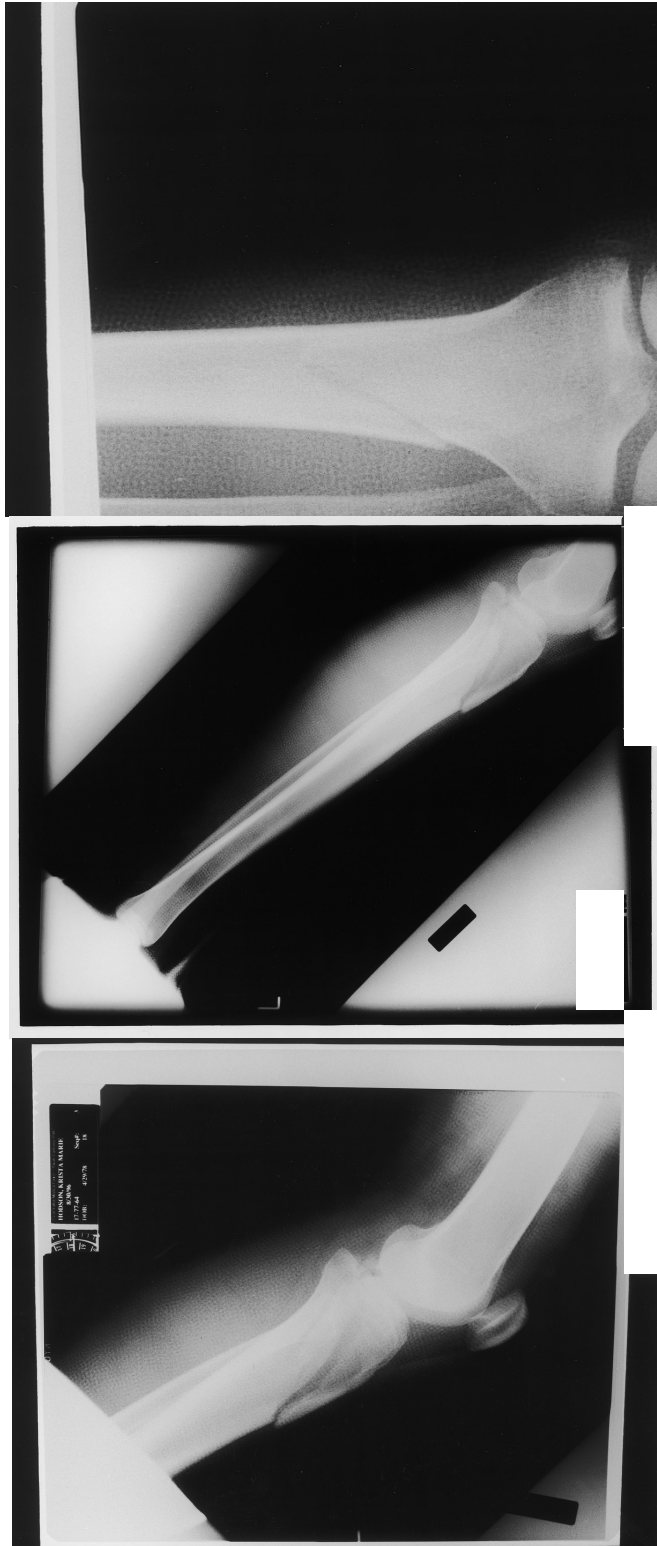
Radiographs of PWC File 1
